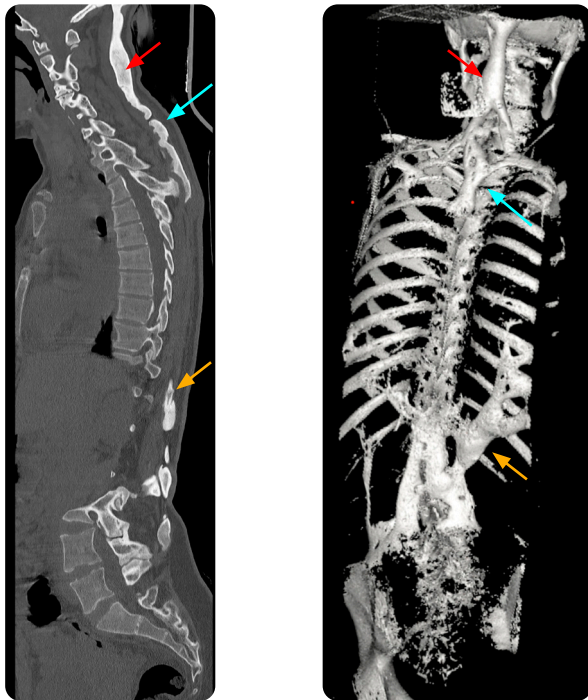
Simple CT of the complete spine. a) Sagittal. b) 3D reconstruction. Multiple prominent heterotopic ossification plaques are observed in the soft tissues adjacent to the cervical posterior arches (red arrow), in the connective tissue covering the dorsal spine and lumbar arches (blue arrow), and in the soft tissues of the right thoracolumbar region (yellow arrow).
